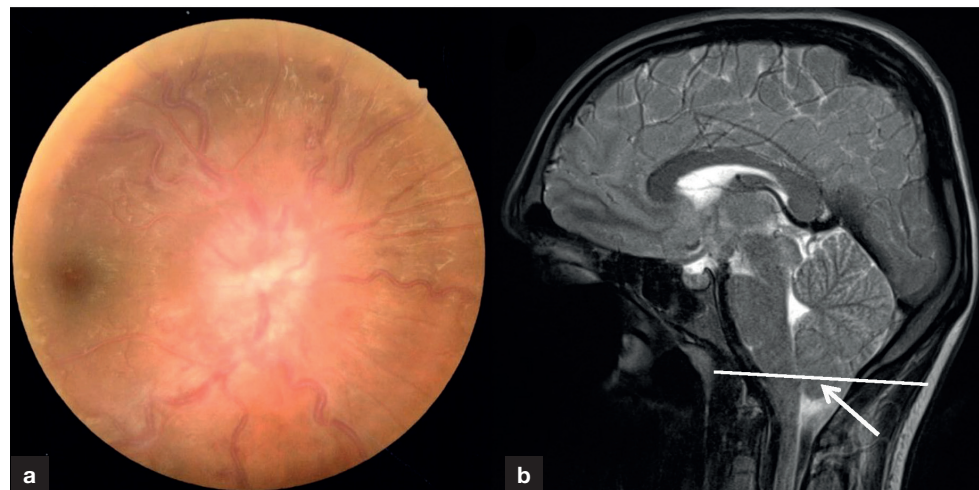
Fundal photographs of the right eye. a. Gross papilloedema with multiple bilateral cotton wool spots, engorgement and tortuosity of the retinal blood vessels, and retinal haemorrhages. Similar appearances were noted in the left eye. b. Magnetic resonance imaging of the brain, T2 sagittal view, shows tonsillar descent (arrow) below the foramen magnum (line).
